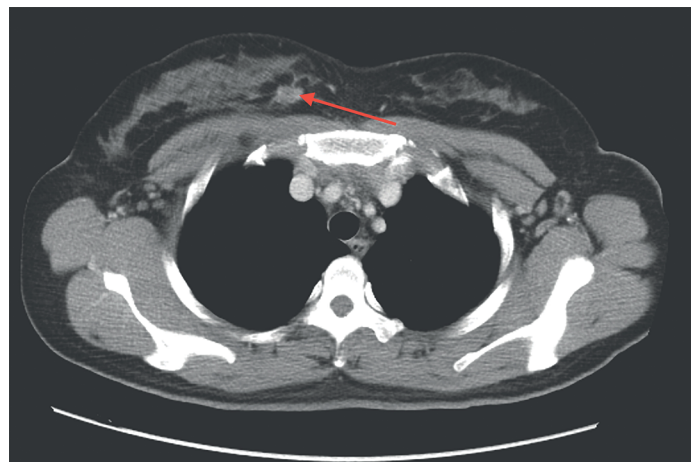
Contrast-enhanced chest CT imaging. Contrast-enhanced chest CT imaging before breast conservation surgery indicated a 1.4-cm diameter heterogeneous mass in the upper inner quadrant of the right breast (red arrow). No enlarged lymph nodes were observed in the bilateral subaxillary, hilar, or mediastinal regions. CT = computed tomography.
